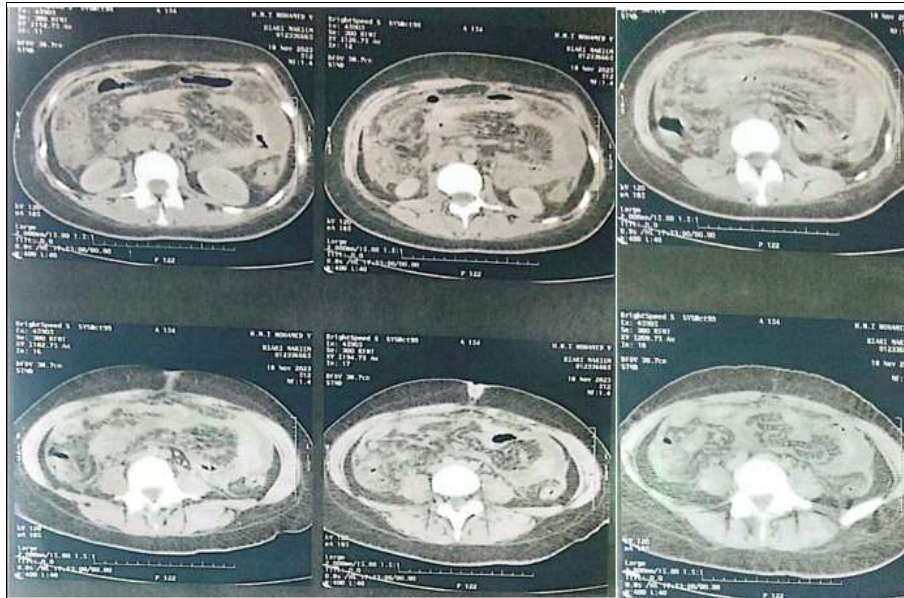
Abdominopelvic CT in axial section after injection of the contrast product.
